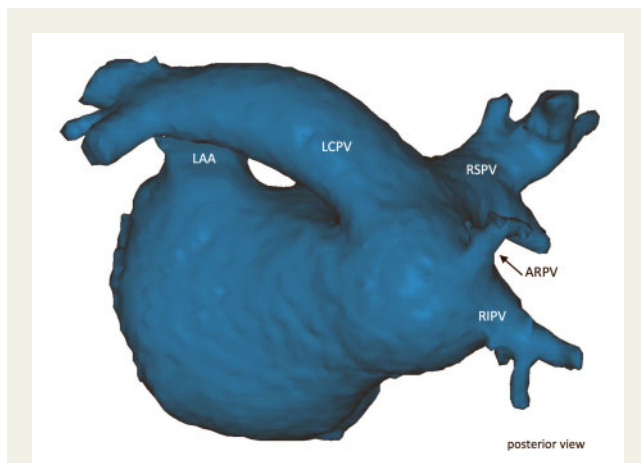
Integrated three-dimensional computed tomography of the left atrium in a posterior view within the electroanatomic mapping system (CARTO[®]3, Biosense Webster, USA). ARPV, right accessory pulmonary vein; LAA, left atrial appendage; LCPV, left common pulmonary vein; MVO, mitral valve orifice; RIPV, right inferior pulmonary vein; RSPV, right superior pulmonary vein.
